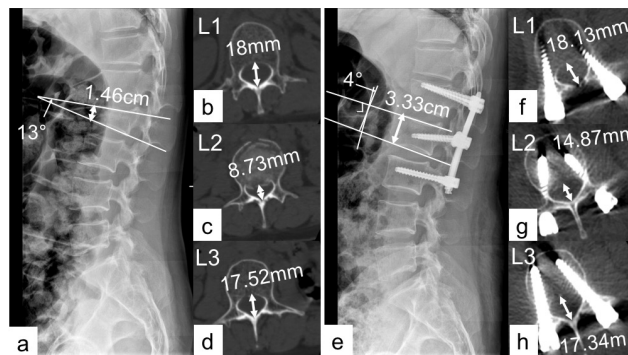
典型病例患者的术前 (a、b、c、d) 及术中 (e、f、g、h) 的 X 线及 CT 的椎体前缘高度、伤椎及相邻上下椎管的椎管容积及 Cobb 角
